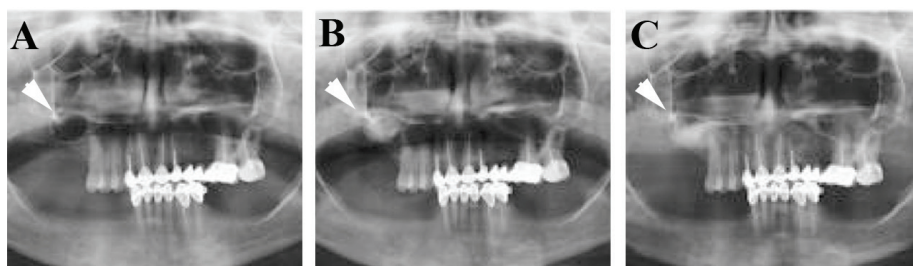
X-ray orthopantomograms. (A) Preoperative; (B) Postoperative; (C) 9 months postoperative. The asterisk shows the Bonelike® implantation site.
